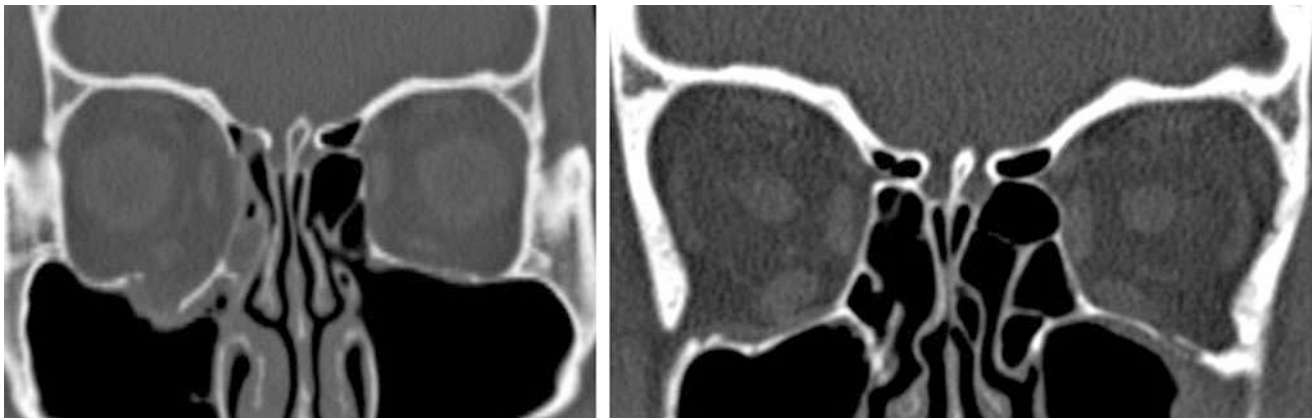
Late postoperative CT scan coronal and sagittal bone windows: Completely healed left orbital floor fracture with implant resorption
